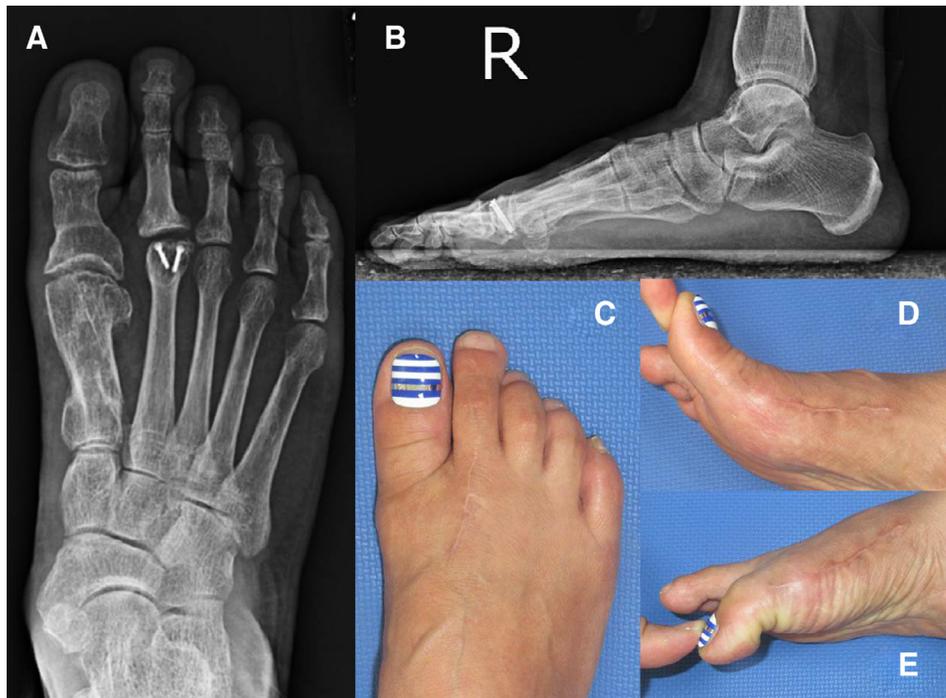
Radiographs at 20 months postoperatively show shortening (A) and lowering (B) of the first metatarsal. The patient was cosmetically satisfied with the result (C), with increased dorsiflexion (D) and constant plantar flexion (E).
